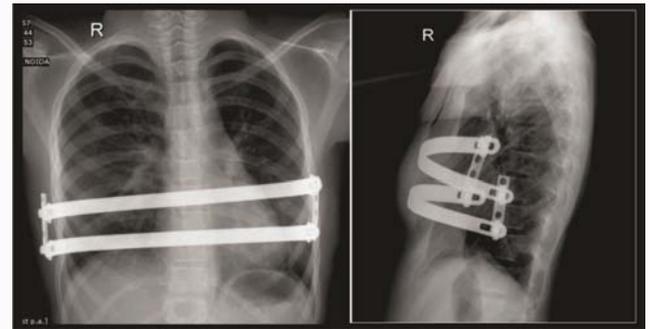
Chest X-ray postero-anterior & lateral view of NUSS procedure with the double bar moon bridge stabilization.
